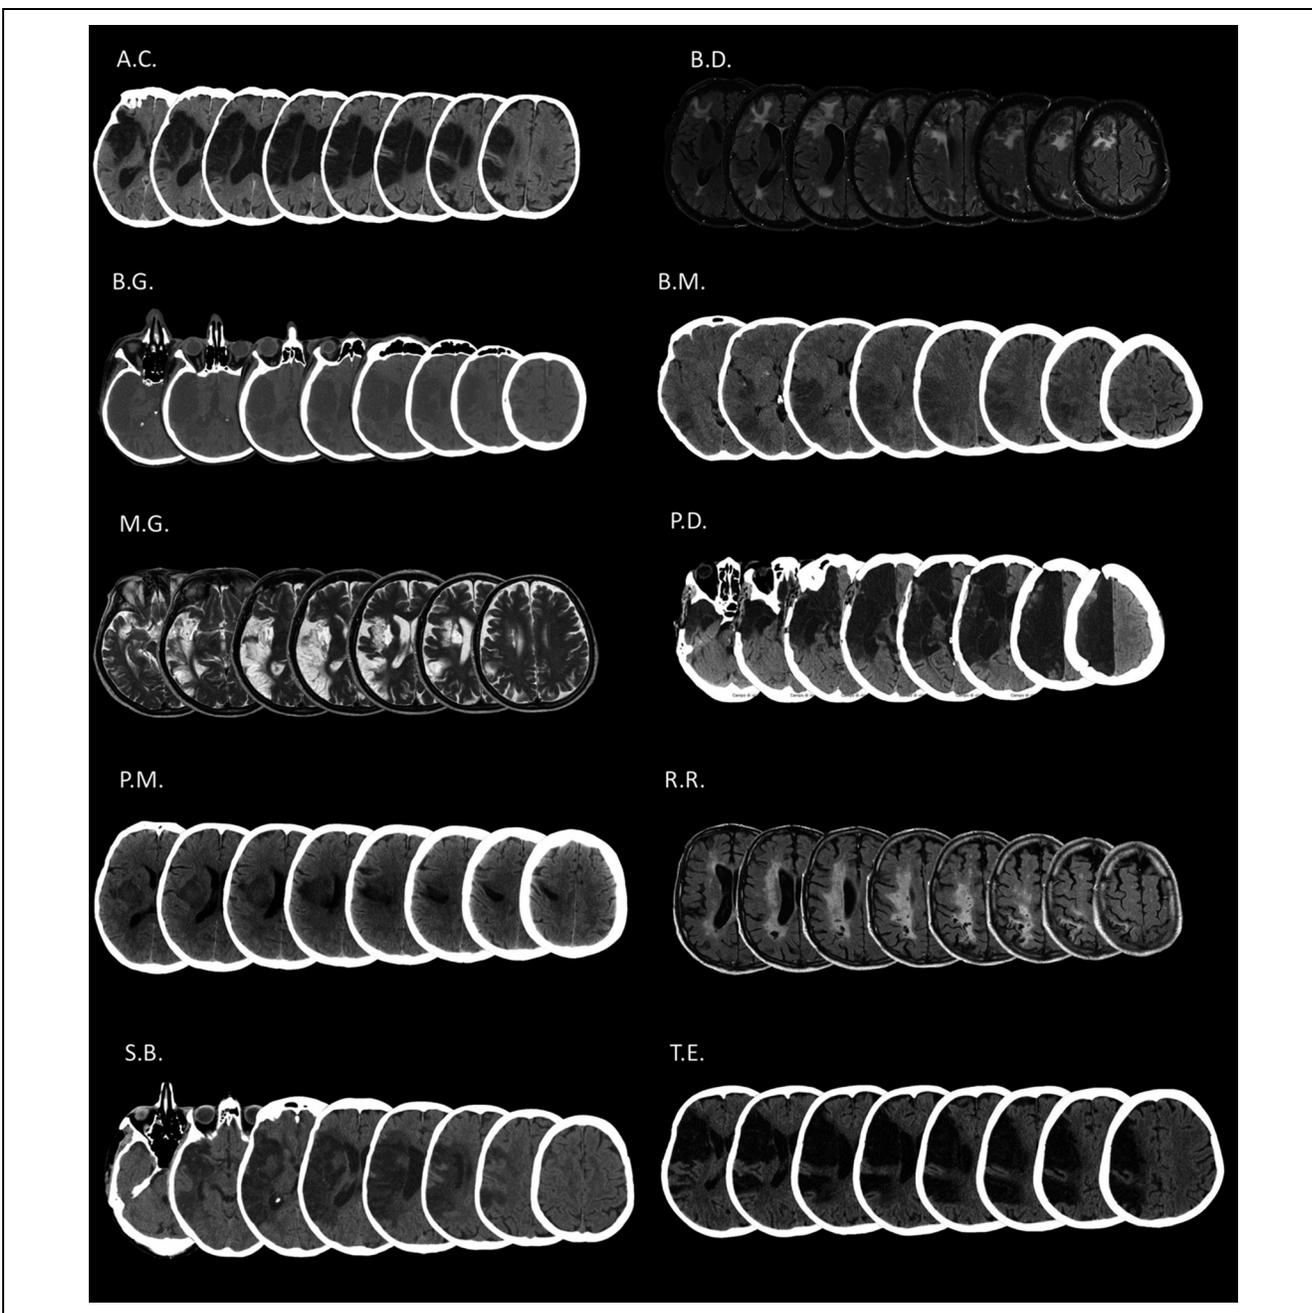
Neuroradiological (CT or MR) lesion documentation for 10 right-brain-damaged participants. Damage involves the territory of the right middle cerebral artery in all cases. Lesions are typically large (with the partial exception of patient PM) and involve both cortical and subcortical structures (with the partial exception of PM and RR, whose lesions are mostly subcortical).
